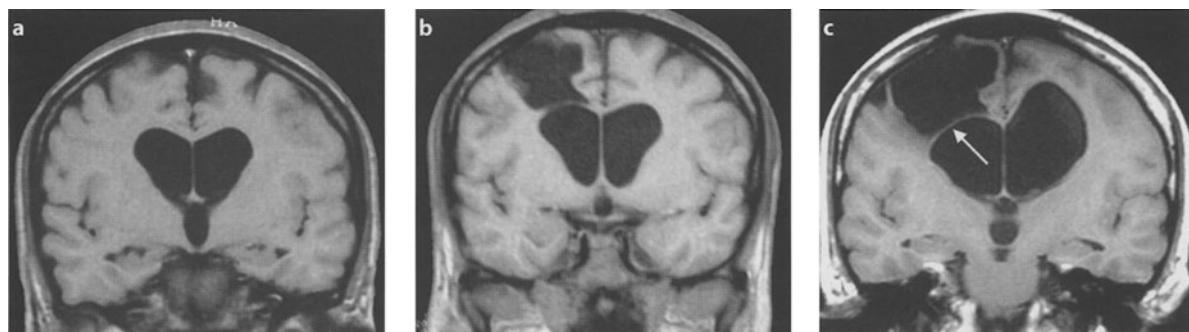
Forty-year-old woman presenting with chronic headache and triventricular dilatation due to aqueductal stenosis. Intracranial pressure monitoring with right frontal intraventricular catheter revealed mild increase of the baseline intracranial pressure (16–18 mmHg). The patient refused operation. a MRI coronal slice before intracranial pressure monitoring. b One year after intracranial pressure monitoring, a large intraparenchymal cavity lined by ependyma reaches the subdural space of the frontal convexity. c Ten years after intracranial pressure monitoring, increased ventricular dilation and enlargement of the frontal cavity lined by ependyma (arrow). The patient presents gait and sphincter disturbances and chronic headaches, but still refuses operation
